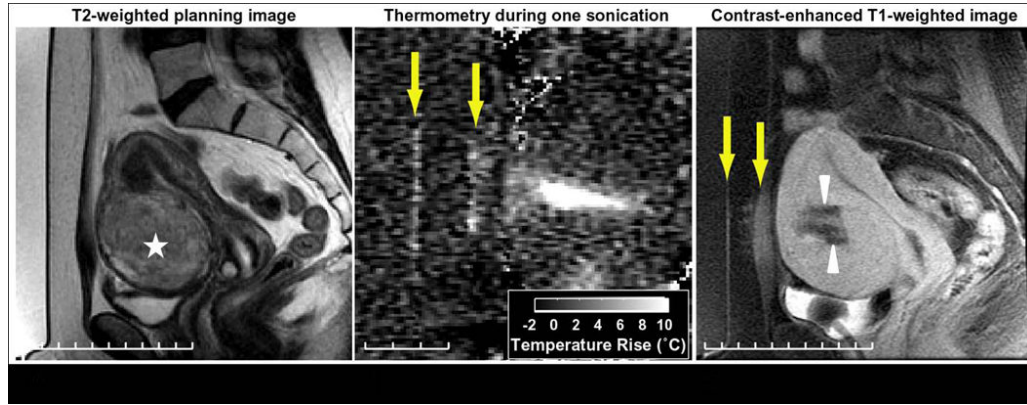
Challenging treatment of hypercellular fibroid and thermal damage outside of the fibroid. (A) On T2 weighted imaging, the hyperintensity of the target lesion (star) indicates that its hypercellular nature requires more energy to ablate it. (B) During treatment, low-level heating is visible in the muscle and skin (arrows) in the thermometry using the proton resonant frequency (PRF) shift technique. Heating is not observed in the fat because the PRF of lipids is not temperature-sensitive. (C) In the contrast-enhanced T1 weighted image performed immediately after treatment, enhancement at skin, subcutaneous fat, and muscle in front of the fibroid in the ultrasound beam path are noted (arrows), indicating thermal damage. This heating, along with skin pain, limited the maximum energy that could be employed and reduced the success of the treatment, which is evident by the sub-optimal non-perfused region (arrowheads). This was asymptomatic and these changes in the fat are no longer visible in the MR after six months.
